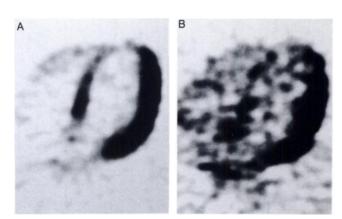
An example of transaxial images obtained during insulin clamping (A) and after acipimox in the fasting state (B) in the diabetic patient with the lowest myocardium-to-blood radioactivity ratio (Patient 12 in Table 1). Higher blood radioactivity levels were seen in the acipimox study compared with those in the insulin clamp method, but the distribution of [¹⁸F]FDG uptake was similar in both studies.
